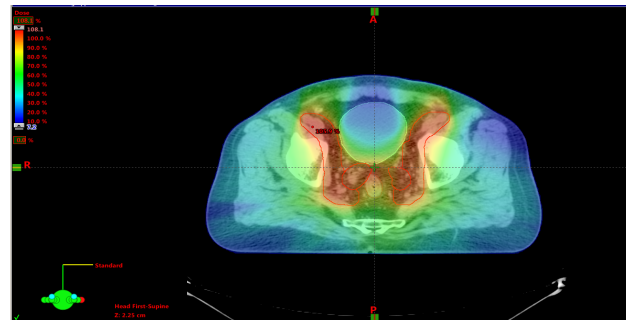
Volumetric Arc Therapy (VMAT), and low dose regions.* Axial cut of the planning CT of the pelvis is represented. Delineated in red is the PTV; the scale on the left up-corner represents the percentages of the total dose (in this case 46 Gy) received by the various body regions. Courtesy of IPO-Porto Radiotherapy department.
